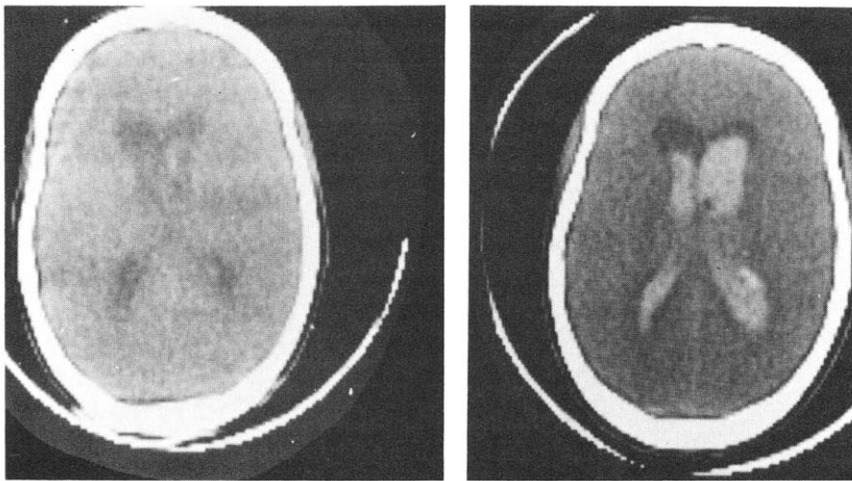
case 7. (Left) CT scan at time of admission (36 weeks gestation) shows a little blood along the margin of the left lateral ventricle. (Right) CT scan on sixth postpartum day shows rehemorrhage.
